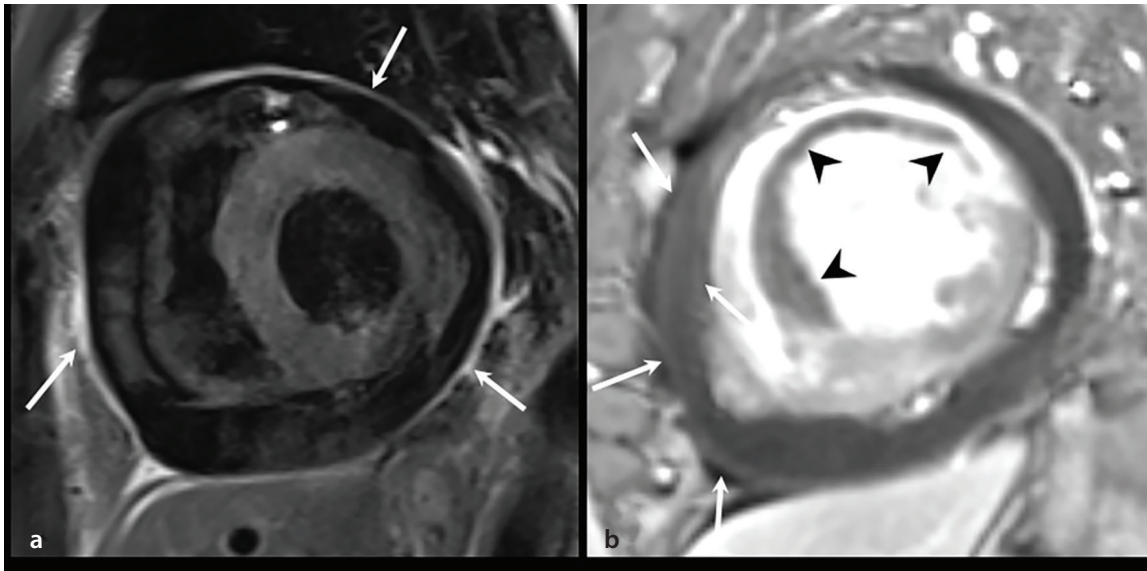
Post-MI pericarditis in a 62-year-old man with reperfused STEMI. (a): Short-axis T2-weighted STIR CMR image shows increased pericardial signal intensity (arrows) reflecting pericardial edema. A moderate amount of pericardial effusion is also seen. (b): Short-axis LGE-CMR image shows increased pericardial enhancement (arrows) suggestive of pericardial inflammation and extensive MVO (arrowheads) in the mid-anterior, anterolateral, and anteroseptal LV walls. STEMI, ST-segment elevation myocardial infarction; LGE, late gadolinium enhancement; STIR, short tau inversion recovery; CMR, cardiac magnetic resonance; LV, left ventricular; MVO, microvascular obstruction.
